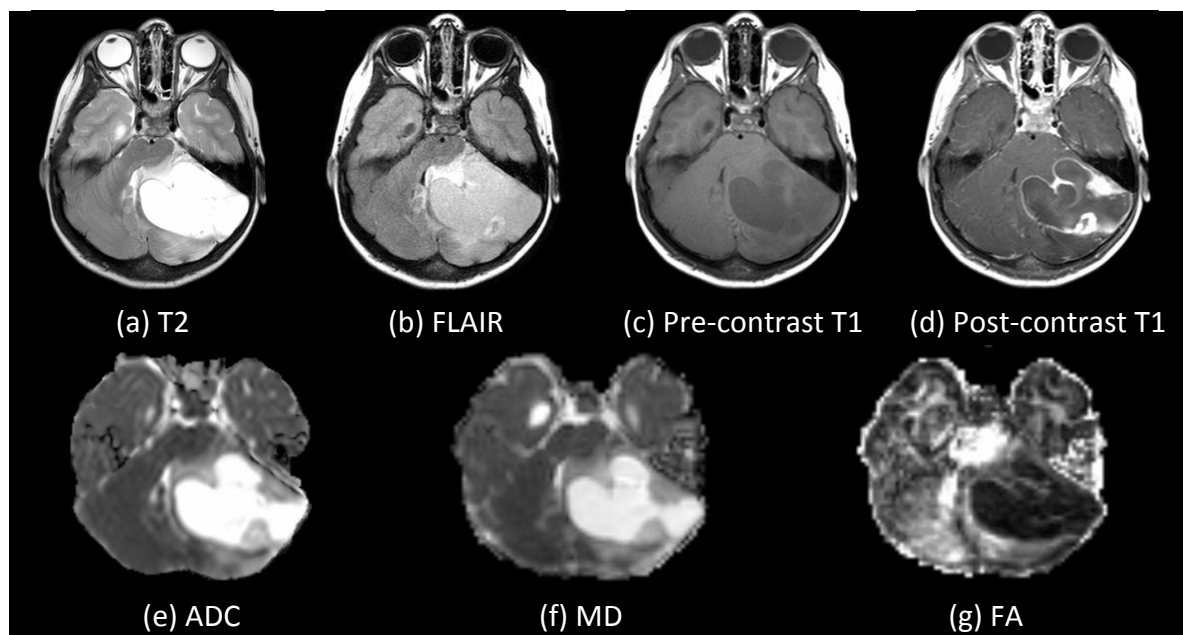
Imaging characteristics of a typical pilocytic astrocytoma based on T2, FLAIR, pre-contrast T1, post-contrast T1, ADC, MD and FA (case PA856).
